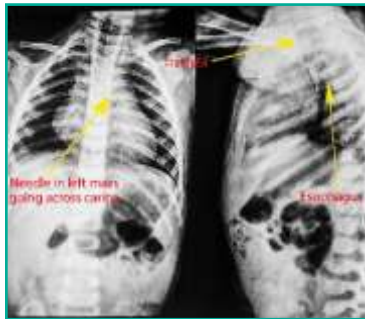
Pre-op Chest X-ray
